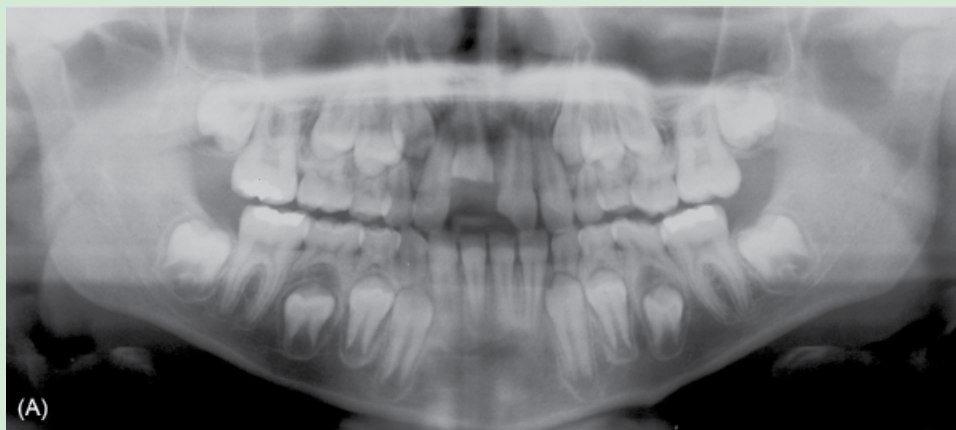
Orthopantomograph (A) and preliminary endodontic treatment of tooth #8 using Ca(OH)_2 (B).
